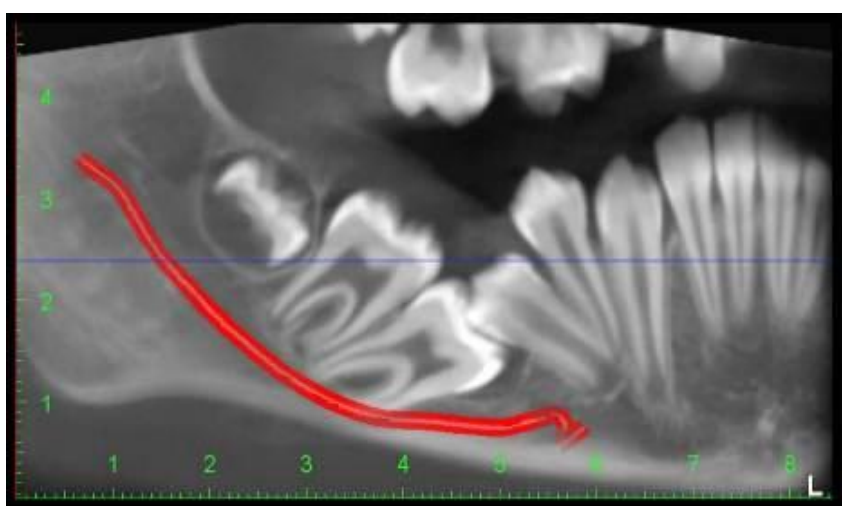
CBCT image showing relation of mandibular canal (red line) to the roots of impacted permanent mandibular first molar
